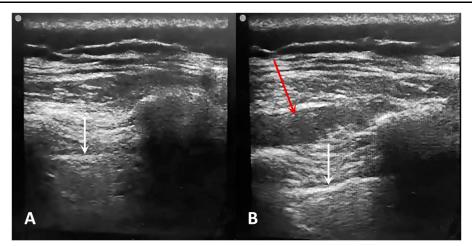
Rhomboid intercostal block. (A) Sonographic anatomy of the layers encountered during the rhomboid block showing the pleura (white arrow). (B) The local anesthetic injected in the plane between intercostal muscles and rhomboid muscle (red arrow).
